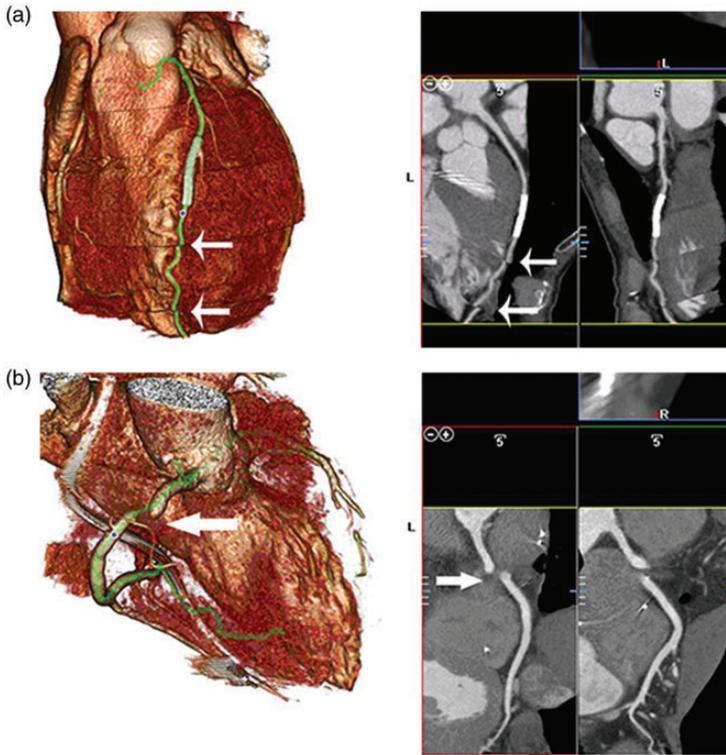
Artifacts affect quality of 64-slice CT images. (a) Stair-stepped artifacts (arrows) in coronary artery imaging in patient with a cardiac pacemaker. (b) Missing data-induced artifacts (arrows) in coronary artery imaging in patient with a cardiac pacemaker.
